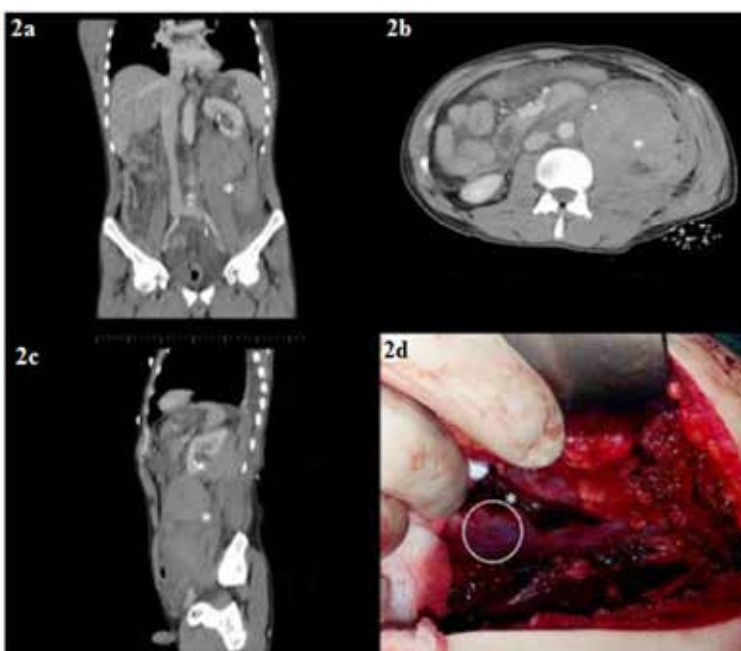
CT view of macro hematoma after microperc.
